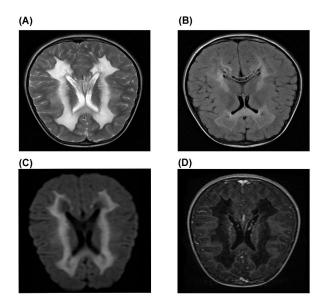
On T2-FLAIR and DWI images (A, B, C) symmetric and diffusely involved bilateral peri-ventricular white matter hyper signal intensity, extended to the level of subcortical arcuate fibers, are seen which appears hypo signal intensity on T1 image (D), compatible with VWM.
